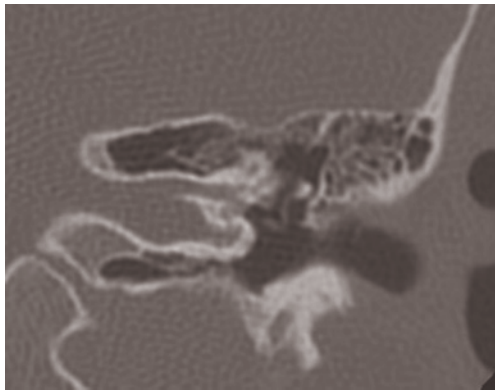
Coronal CT scan. Left internal auditory canal enlarged and bifid.
